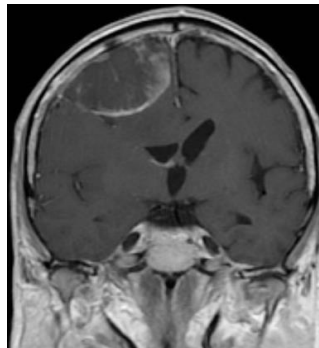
showing MRI brain coronal cut with Post-embolization central necrosis
